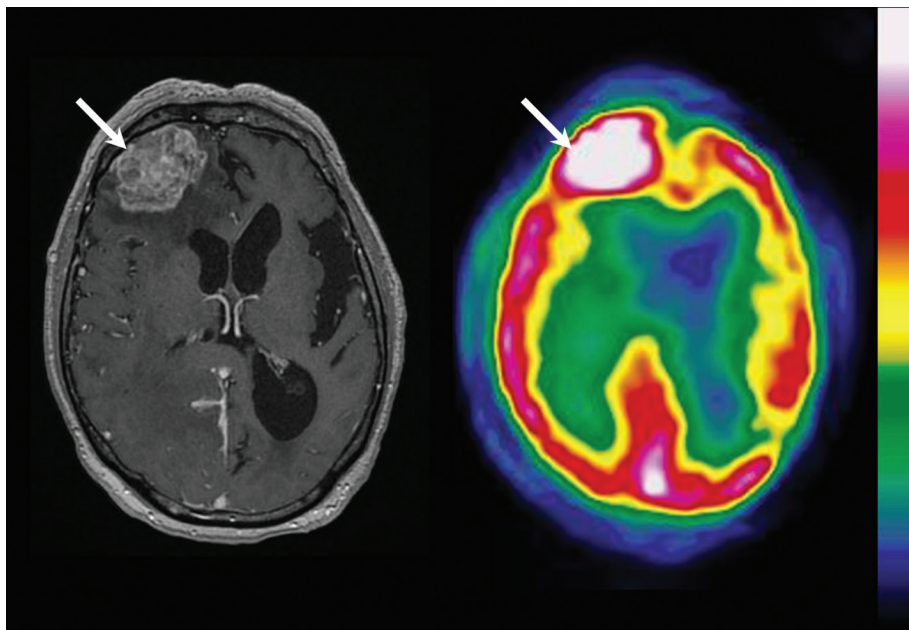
Primary diagnosis of a right frontal glioblastoma in a 79-year-old man following acquisition of axial slices of T1-weighted gadolinium-enhanced MRI (left side) and ^{18}F -FDG PET (right side). The right frontal glioblastoma is contrast-enhanced on MRI (white arrow) and shows an extensive uptake of ^{18}F -FDG PET (white arrow), despite the high uptake in surrounding normal brain tissue.
